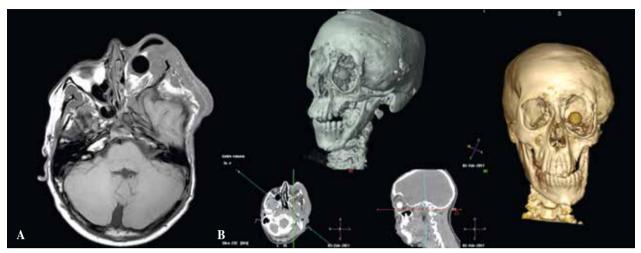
Preoperative images: A) MRI coronal cut, demonstrating a large left hemifacial tumor. B) Bone deformity 3D reconstruction.
